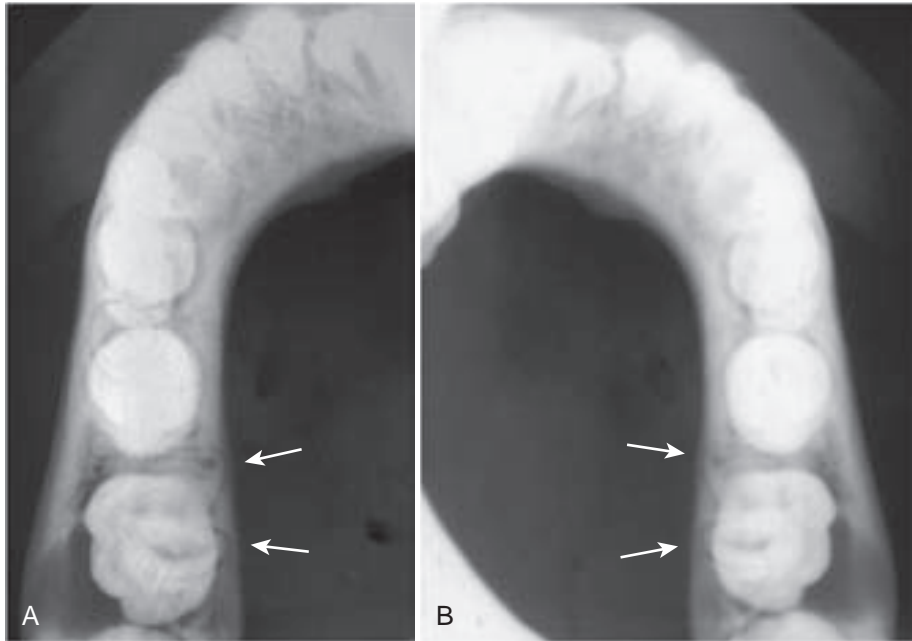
Mandibular buccal bifurcation cyst in one patient. A, Occlusal radiograph showing lingual displacement of roots of first molar on right and buccal radiolucency. B, Occlusal radiograph showing displacement of roots of first molar on left and buccal radiolucency. (Courtesy of Dr. Bernard Friedland, Harvard School of Dental Medicine, Boston)
